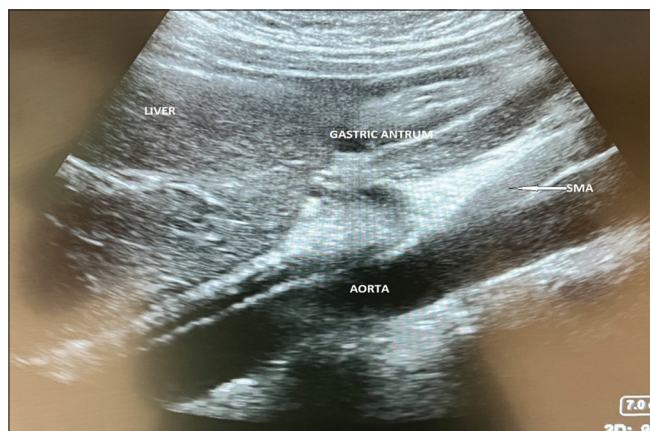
Sonographic image of the gastric antrum of an empty stomach in an additional study patient. Once again, the antrum appears flat and collapsed, with no visible content (Grade 0); SMA, superior mesenteric artery
